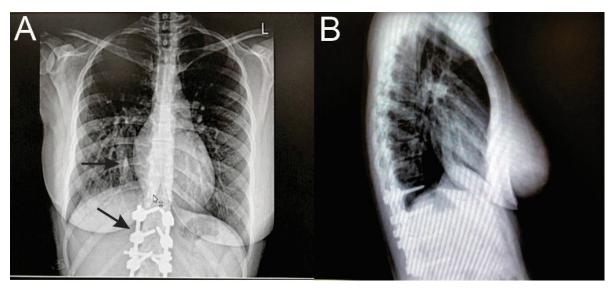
Chest x-ray showing a scimitar-like abnormal shadow in the right lower lung field (arrows). The lower arrow demonstrates the history of previous thoracic spinal injury.
